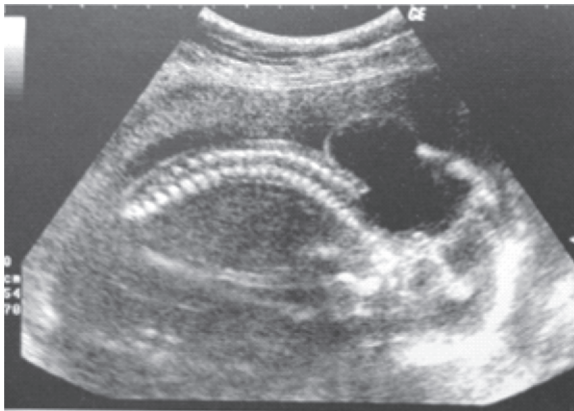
Fetal Anencephaly on ultrasound
